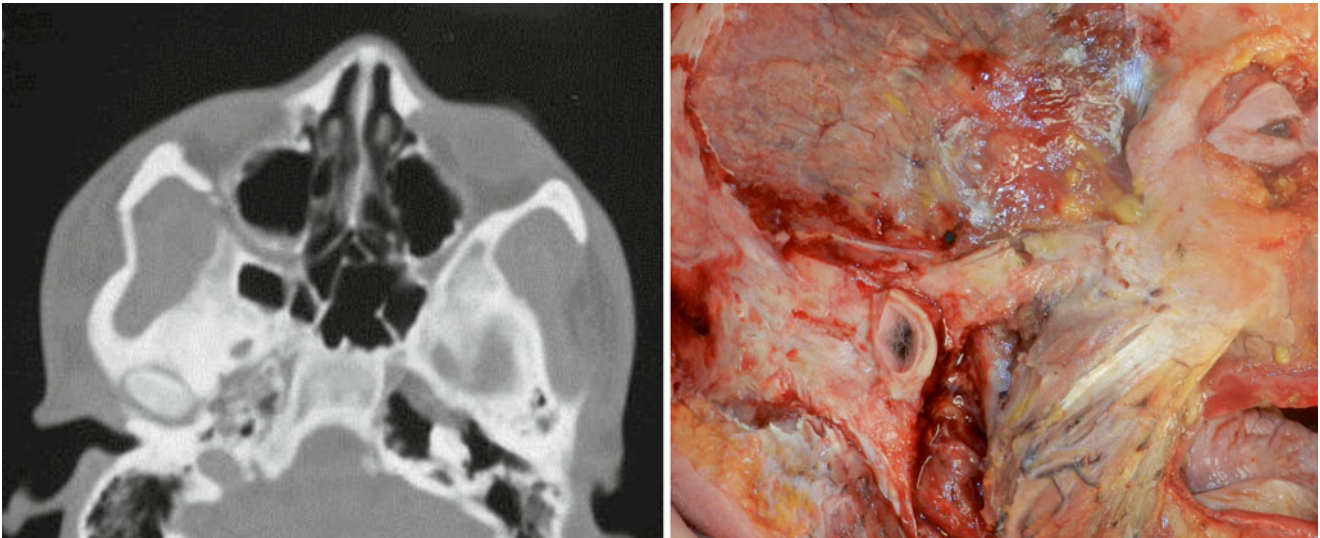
Isolated right zygomatic arch fracture as seen on axial CT scan and prosection
